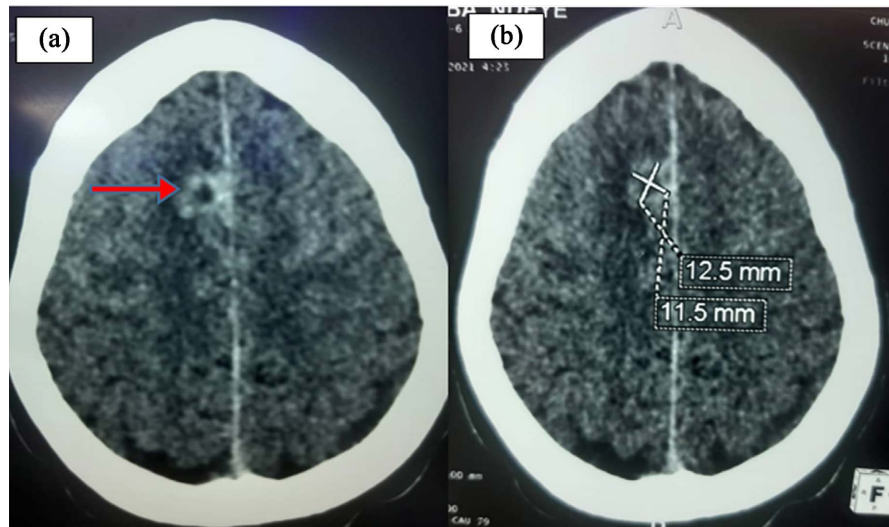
Cerebral computed tomography images with injection of contrast product on admission of the patient showing the cerebral abscess, (a) Demonstration of a hypodense parenchymal lesion with peri-lesional peripheral enhancement (red arrow), (b) Measurement of lesion.
